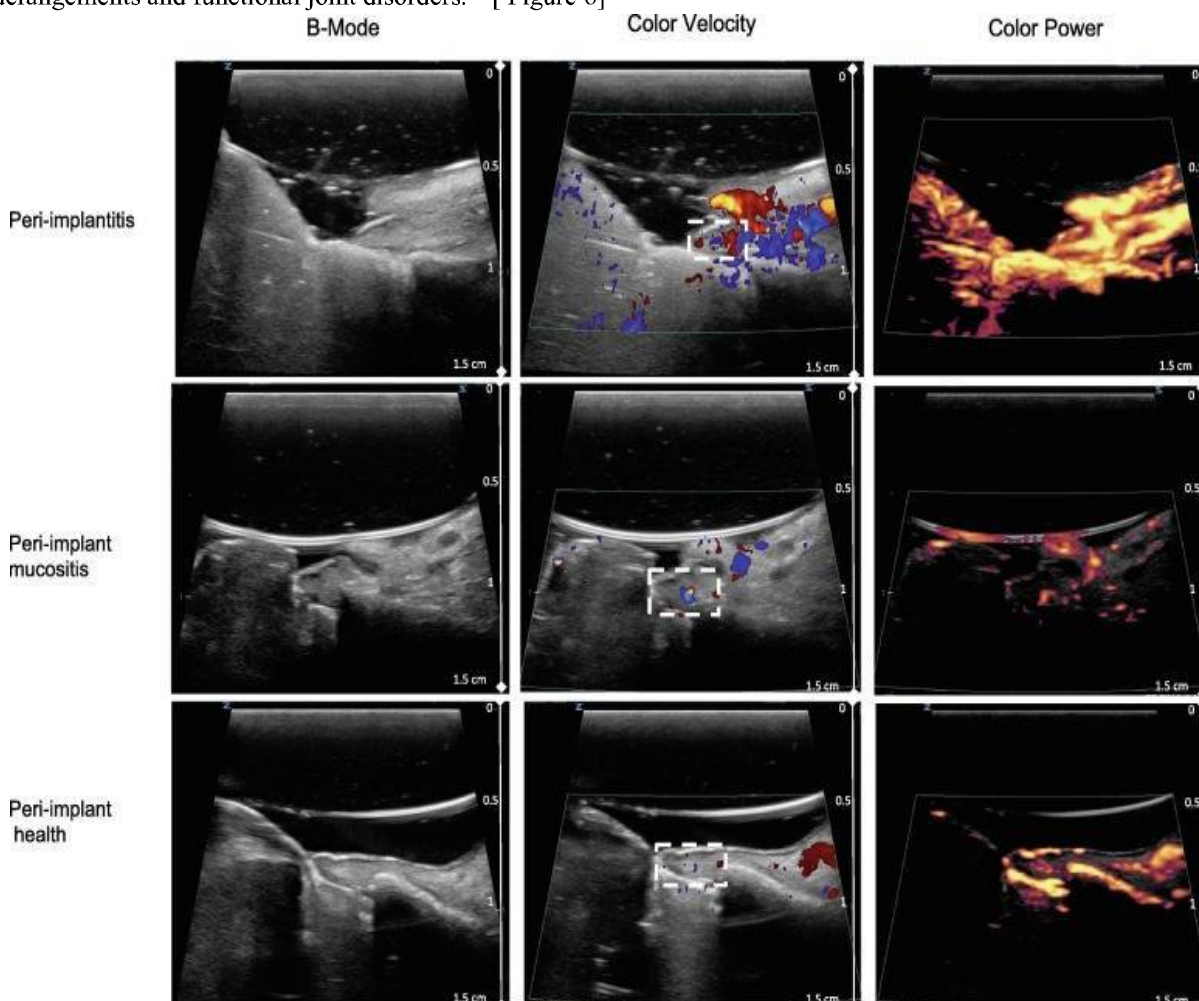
Ultrasound in Peri –Implantitis
